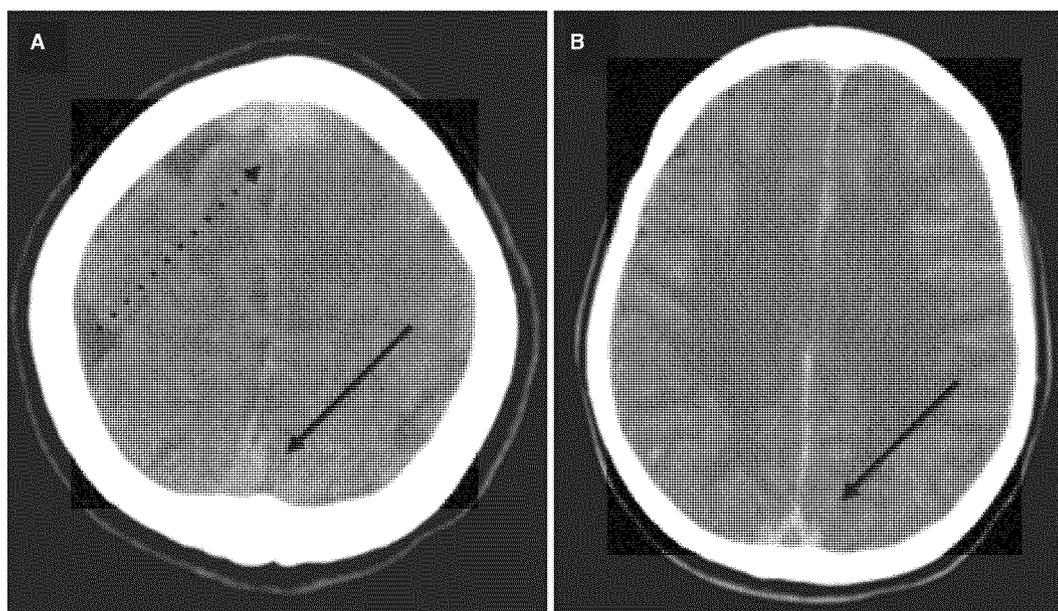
Superior sagittal sinus thrombosis on computed tomography (CT) scan. (A) Unenhanced CT scan showing the dense triangle sign (arrow) and a peri-thrombotic frontal hemorrhagic suffusion (dashed arrow). (B) Enhanced CT scan showing the empty delta sign (arrow) of the superior sagittal sinus.
